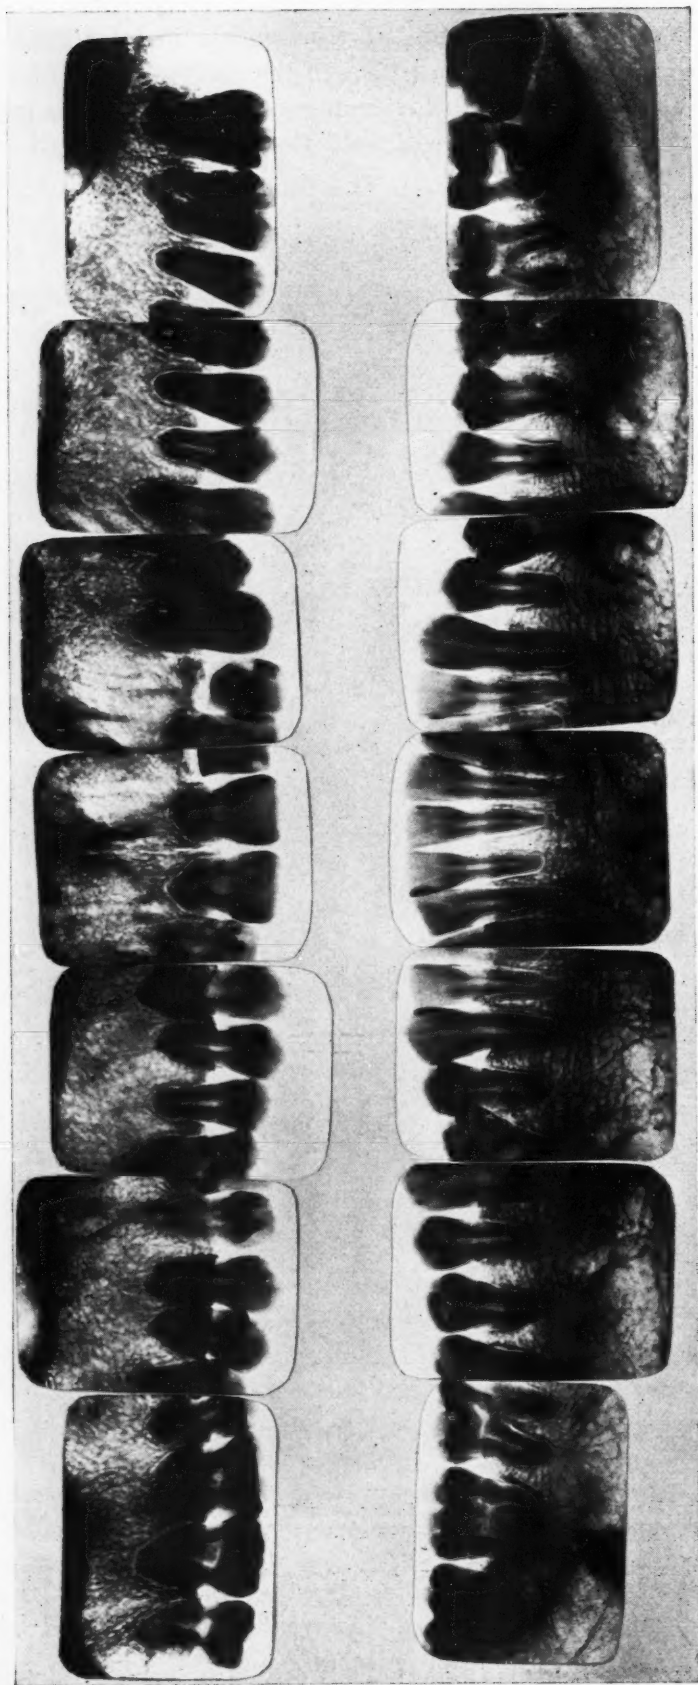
Roentgenograms of the teeth in a skull labelled "Mexican Peon," Northwestern University Museum, Chicago. Note extensive resorption of the roots of nearly all the teeth.
